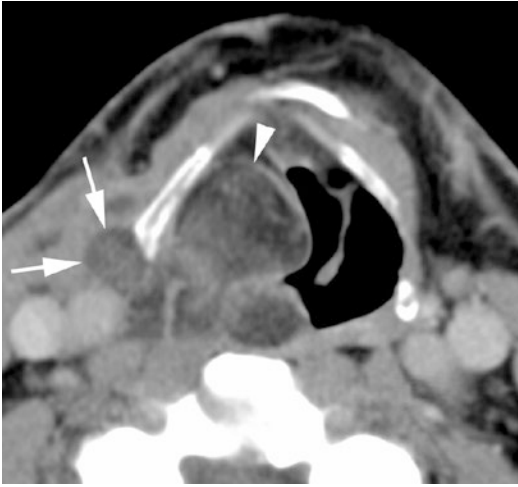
Axial contrast-enhanced CT image. Soft tissue mass centered in the right paraglottic space (arrowhead), extending into the hypopharynx as well as extrapharyngeally (arrows). The tumor appears inhomogeneously, consisting of tissue with negative and positive density values. Liposarcoma
